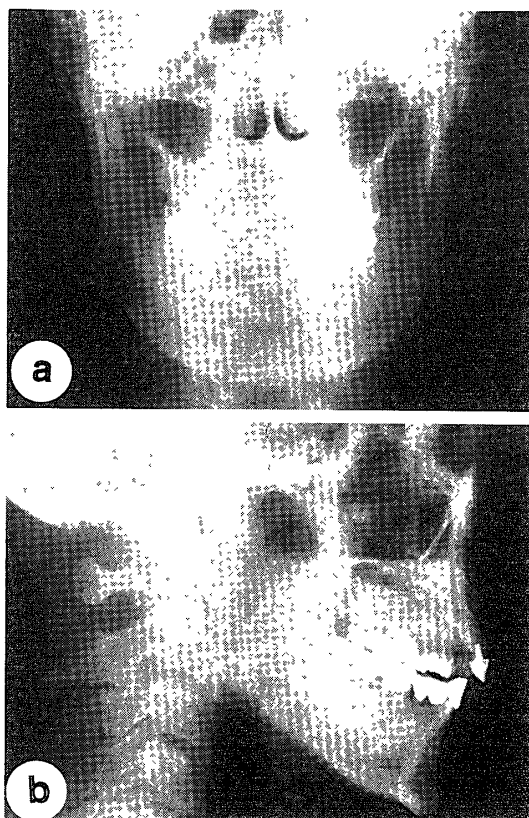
Posteroanterior (a) and lateral (b) radiographs obtained at the first admission.
